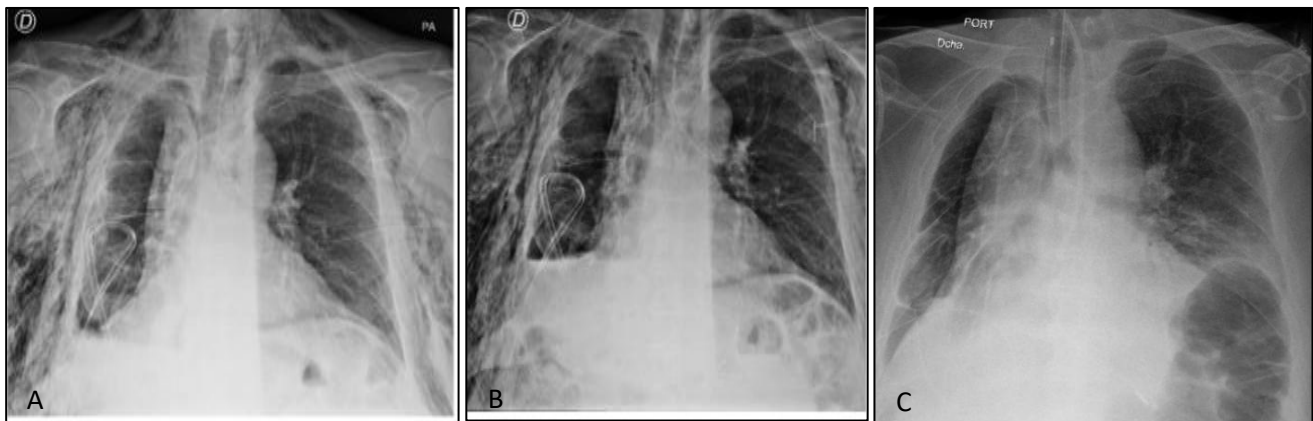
(A-C): Progressive subcutaneous emphysema and persistent pleural disease on serial chest radiographs (A) Jan 4, (B) Jan 5, 2026. C-Persistent pleural disease and reduced right lung volume during final readmission.
